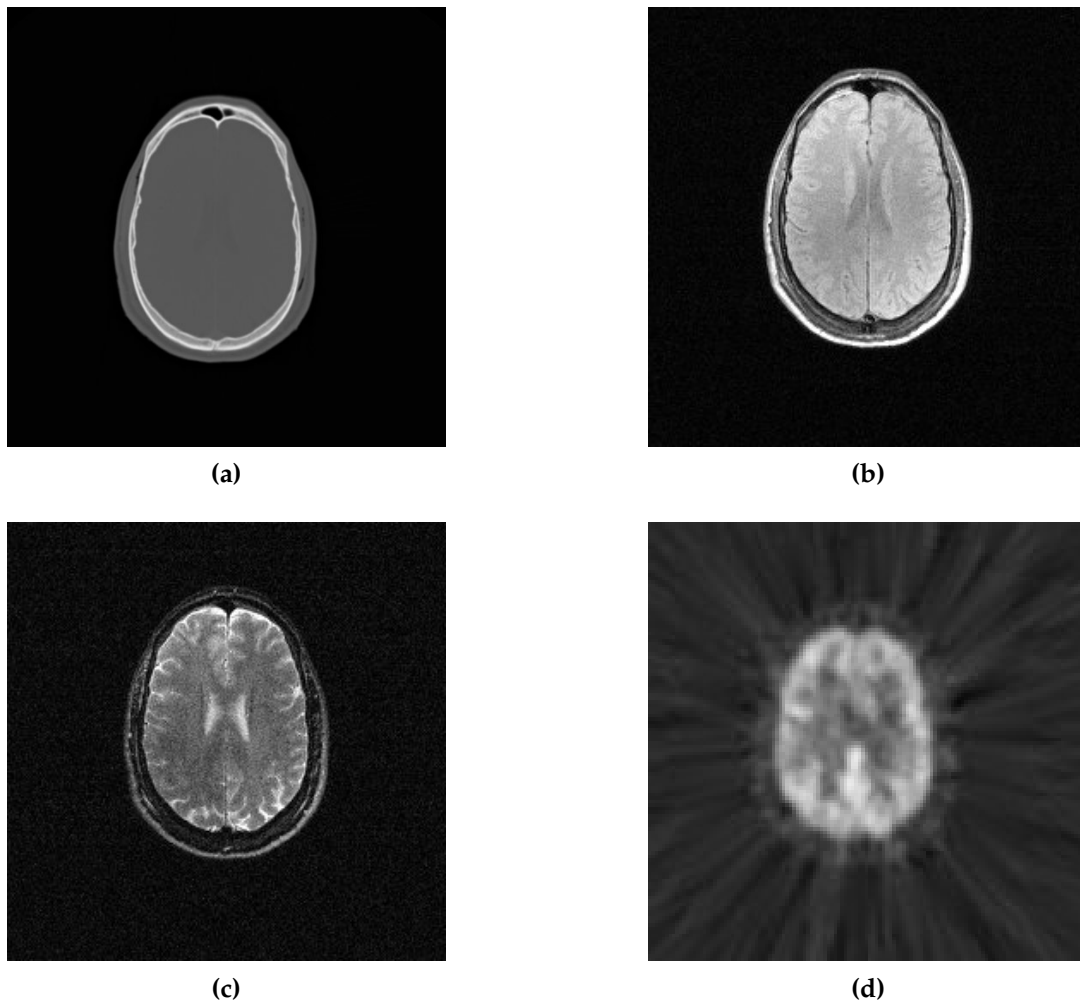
Axial views of the data chosen from patient_001 of the Retrospective Image Registration Evaluation (RIRE) Project: (a) CT; (b) MR_PD; (c) MR_T2; (d) PET.*
